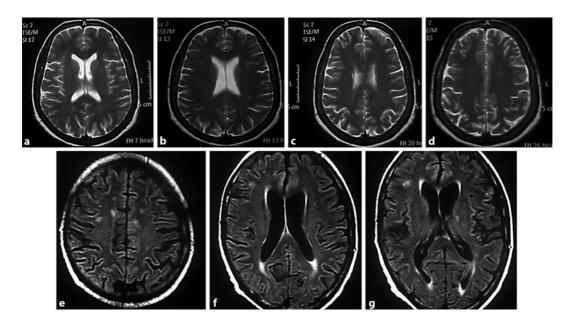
The second MRI series of the brain in 2005. Axial T2-weighted (a–d) and FLAIR sections (e–g) show several periventricular and subcortical plaques.
